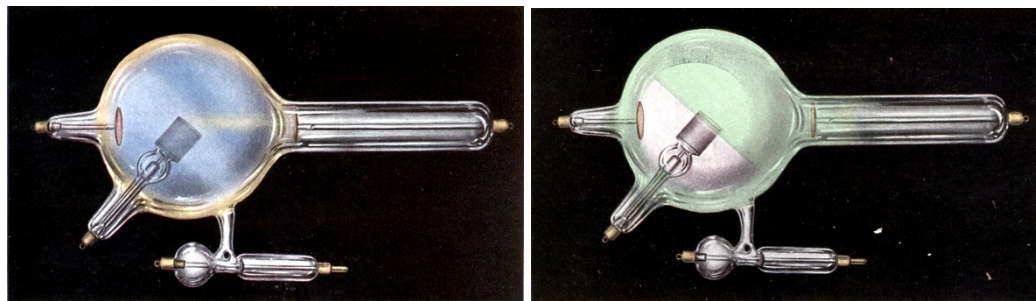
Gas X-ray tubes. The one on the left shows too low of a vacuum, the one on the right shows a good level of vacuum.²⁹⁵
